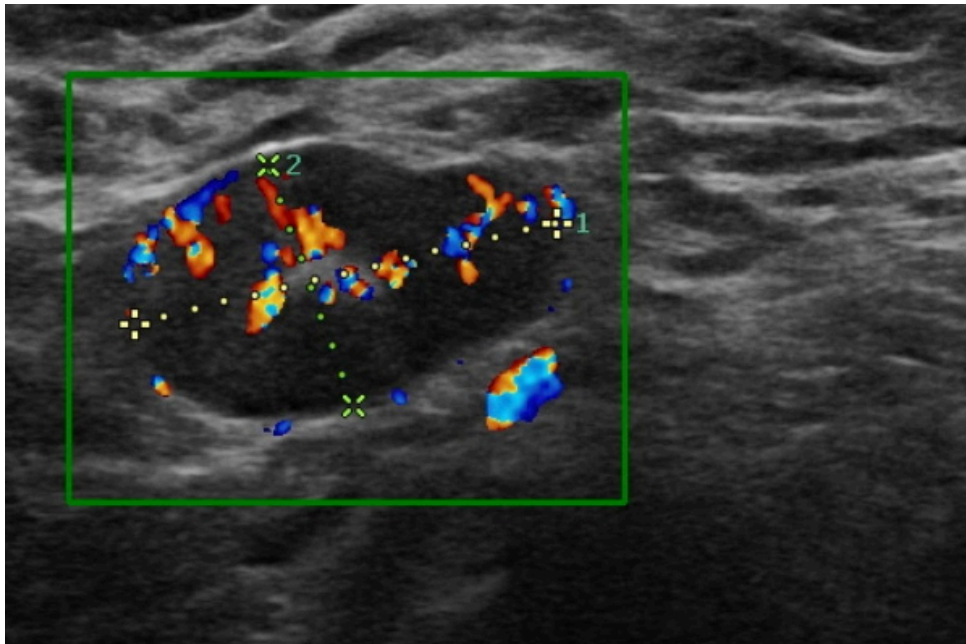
Ultrasound of an axillary lymph node with diffuse cortex thickening and peripheral type of vascularisation, metastasis was confirmed.
